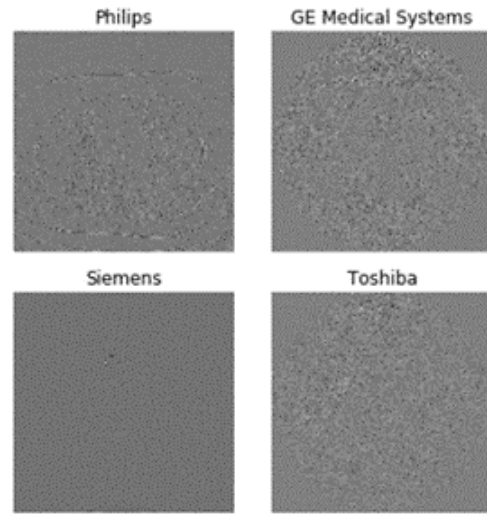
Example of extracted noise patterns from several CT slices.
